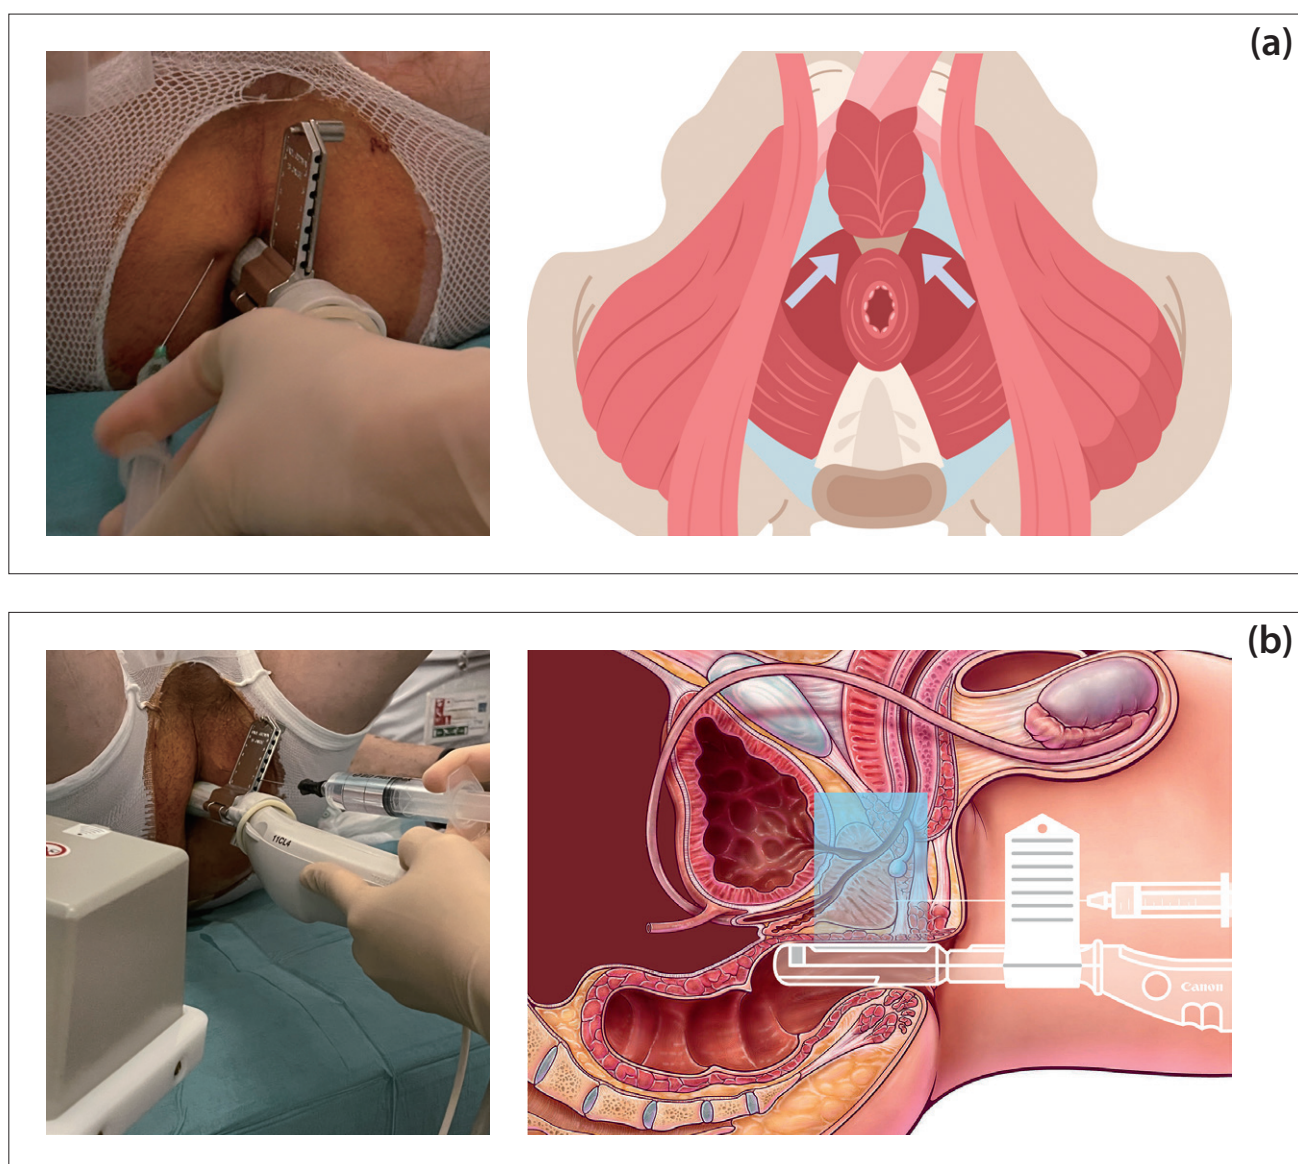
Local anesthesia in two steps: (a) wide-area anesthesia of the perineal skin, (b) deep prostatic nerve block under ultrasound guidance, divided into two injections, one on each side of the neurovascular bundle.
